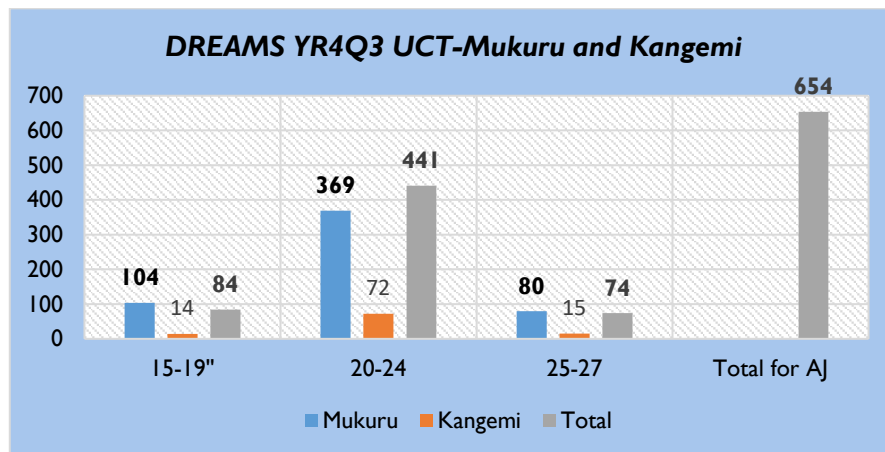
Below depicts the CT disbursement across the age cohorts
